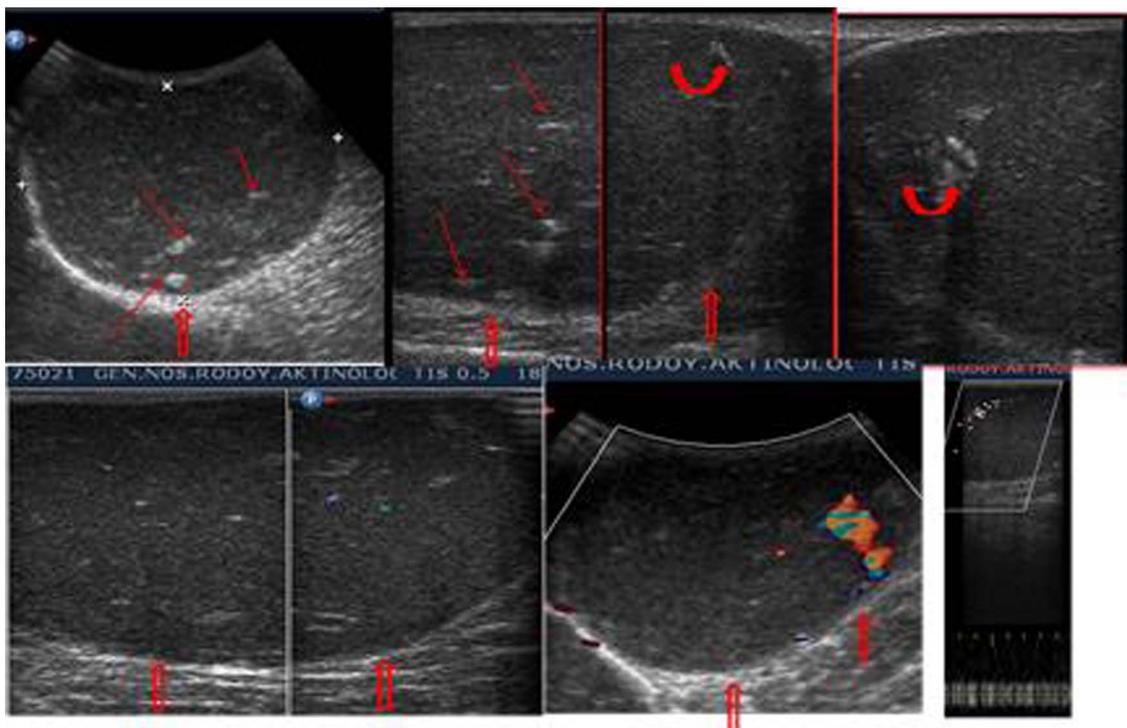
Ultrasound imaging showing internal echogenicity debris (arrow), prominent calcifications (curved arrow) and peripheral hypoechoic capsule mass blood supplied (open arrow).
